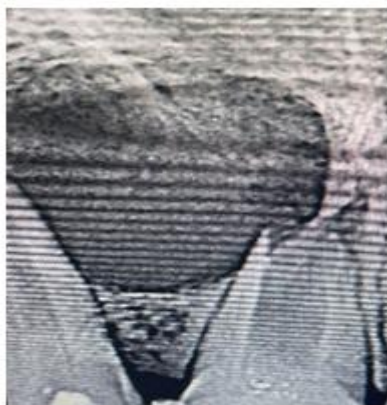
Inter appointment radiograph
